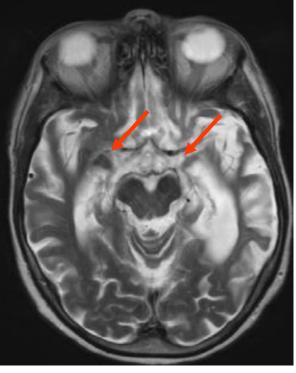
Alzheimer global cortical atrophy and hippocampal atrophy (arrows) on T2-weighted image. Compare image with Fig. 9 (normal brain without atrophy).
